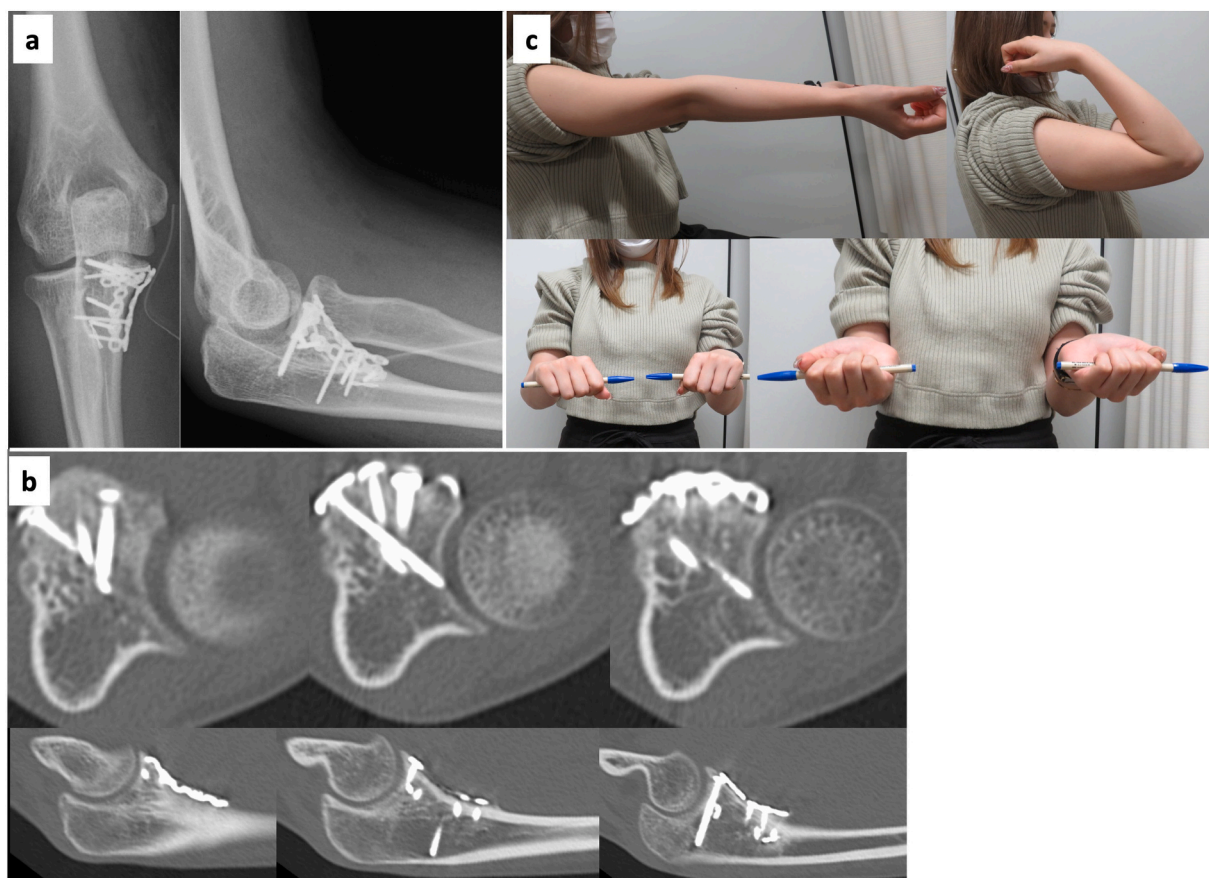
a: Postoperative plain radiography showed the restoration of satisfactory alignment.
